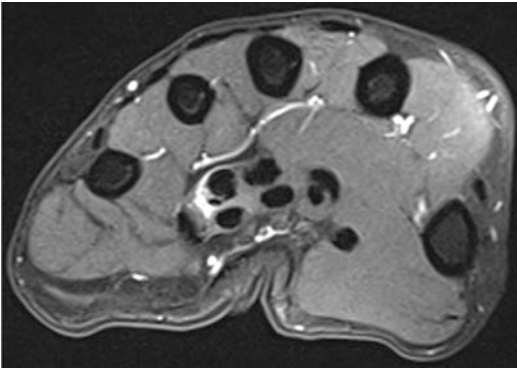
Axial PDfs MRI: hyperintense hematoma surrounding the fourth flexor digitorum profundus tendon with tear of the lumbrical muscle tendon at the origin in the sense of a grade III lumbrical shift syndrome
